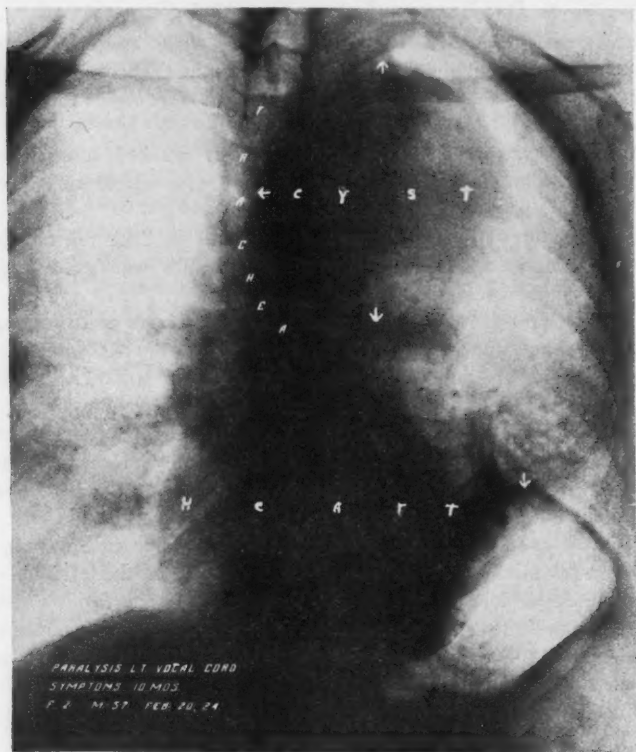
Case of paralysis of left vocal cord, due to mediastinal dermoid cyst as indicated by four arrows. Note pressure on left bronchus and displacement of trachea to the right. Eventration of diaphragm on left indicated by arrow. (Radiograph by Dr. L. T. LeWald.)
